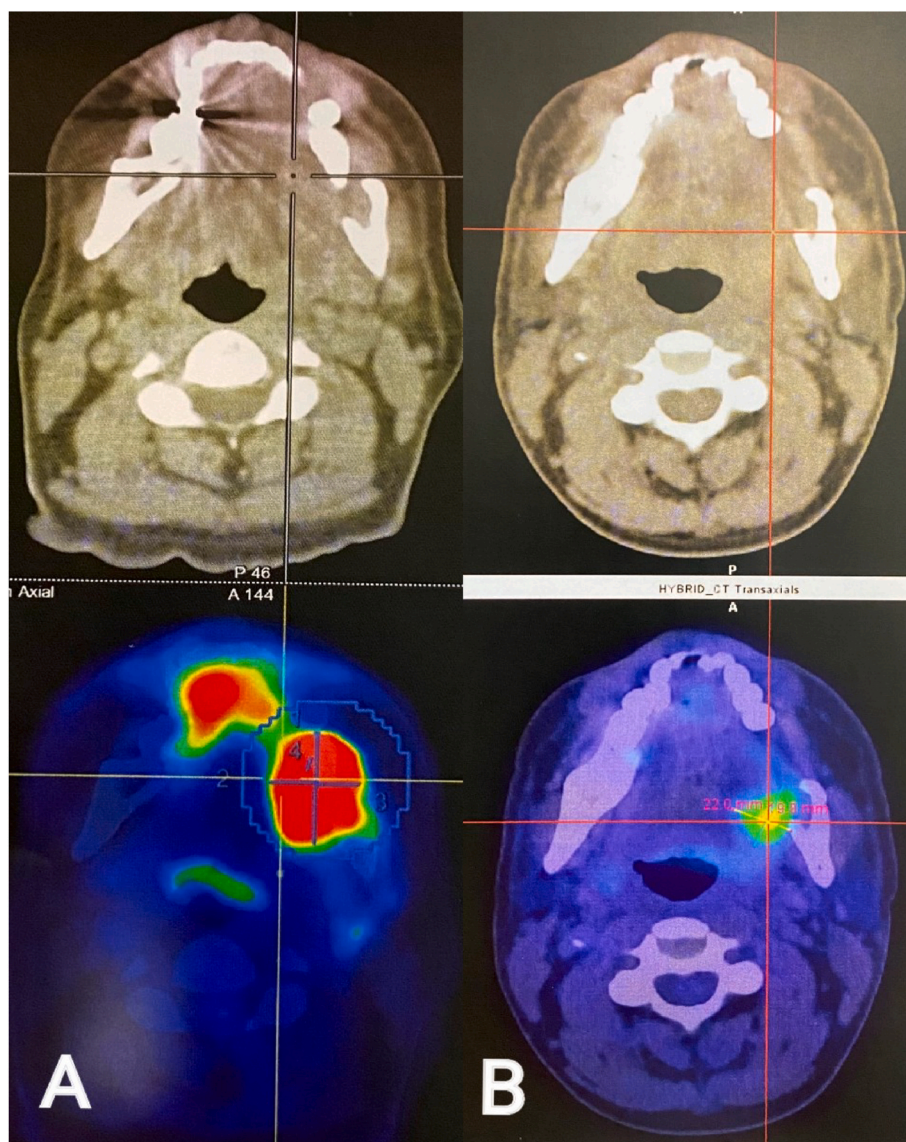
A. Pre-treatment 18-FDG PET/CT result: There are two tumors in Upper gingival (L) (SUVmax 23,7) and hard plate (SUVmax 12,2) B. Post-treatment 18-FDG PET/CT result: partial response, there is still a mass (SUVmax 6,4).
